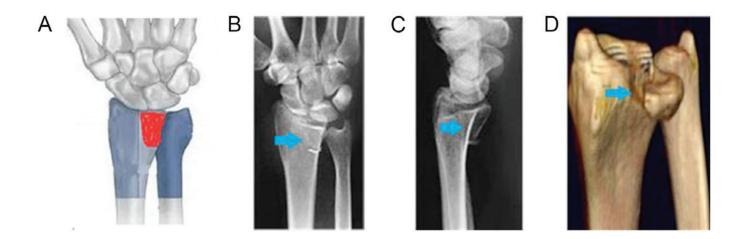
Single-column die-punch fracture. (A) Sketch of a single column die-punch fracture (red area indicates fracture site). (B) Anteroposterior and (C) lateral radiographs. (D) CT image. Arrows indicate the fracture site.
